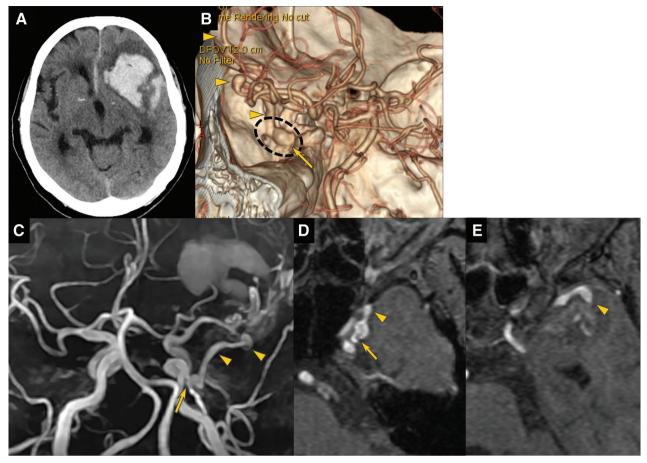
(A) Cerebral hemorrhage was noted in the left frontal lobe on CT at the first examination. (B) DAVF (dashed circle) with a shunt point (arrow) inferior posterior to the left cavernous sinus was noted on 3D-CTA. Blood directly flowed into the superficial
